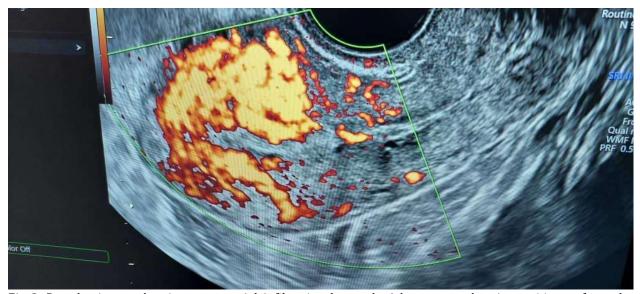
Doppler image showing myometrial infiltration by grade 4 hyper vascular tissue, 11 mm from the posterior uterine serosa, 12.4 mm from the fundus, but approaching the anterior uterine serosa.
